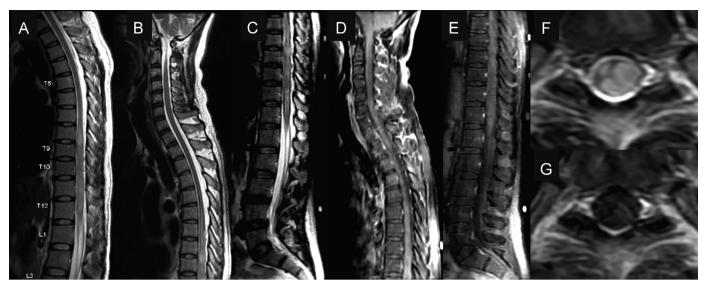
Serial MRI spine from 2008 to 2009. (A) MRI spine showing T2-hyperintense lesion from T8 to T12 with cord expansion in 2008. (B, C) Rostral extension of T2-hyperintense lesion to T6 with cord expansion and (D, E) subtle patchy contrast enhancement in 2009. (F) Axial imaging showing the lesion occupying nearly the entire cross-section of the cord at T8 with (G) subtle contrast enhancement in 2009.
